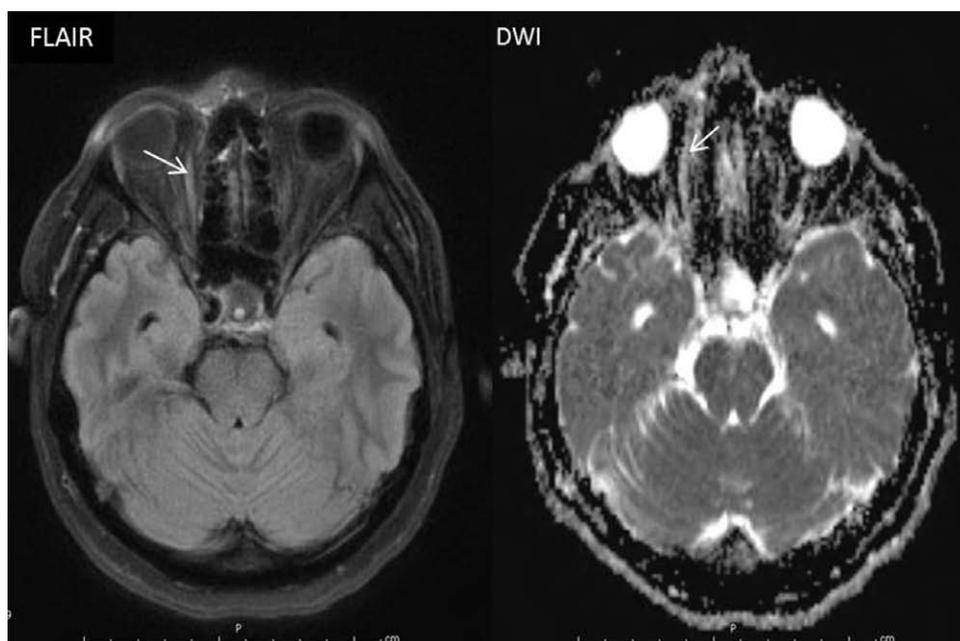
MRI head and orbit: FLAIR and DWI images demonstrate right medial rectus ischemia. DWI, diffusion weighted image.
